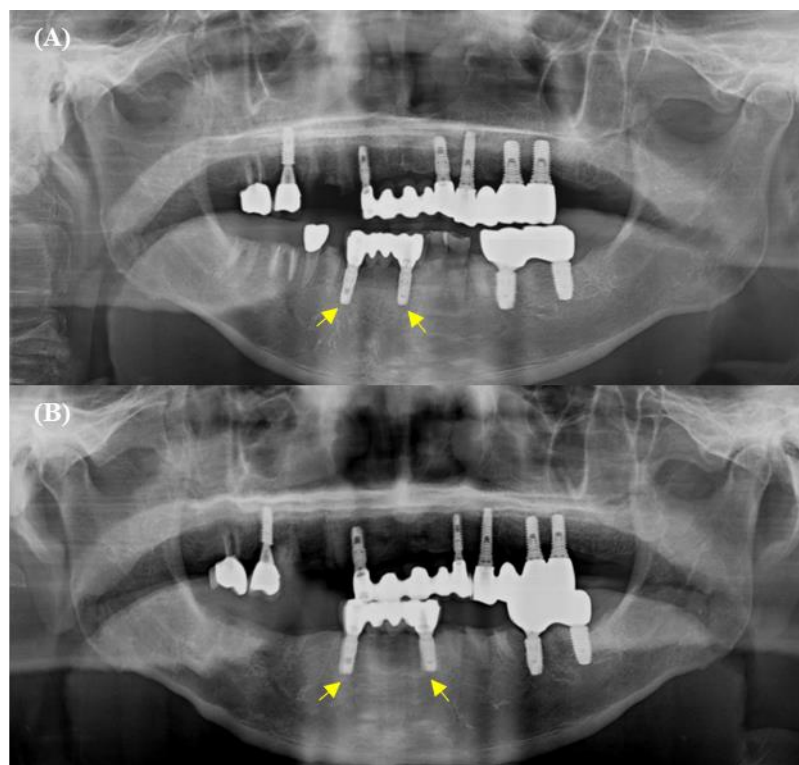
MRONJ case 1; (A) Panoramic radiograph taken at the initial visit, showing a MRONJ lesions around implants in the right anterior mandibular region. (B) Panoramic radiograph showing follow-up findings in the same area. Yellow arrows indicate areas of MRONJ lesions.
